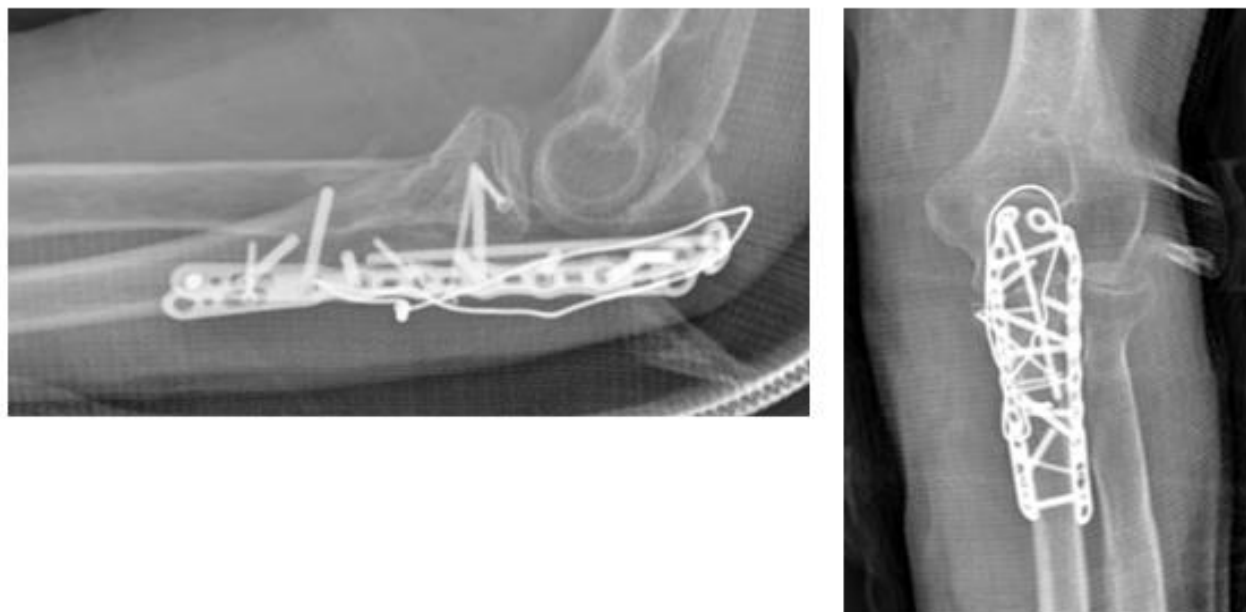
Case 2 - Post-operative lateral and anteroposterior X-Rays after 2nd surgery: ulnar nerve neurolysis with submuscular anterior transposition and K-wire hardware removal (cerclage wire did cause neither prominence nor intolerance, therefore it was not removed)
